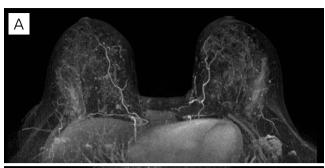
After treatment, axial magnetic resonance imaging (A) T1; (B) T2 STIR; (C) and (D) subtraction, inflammation resolution.
